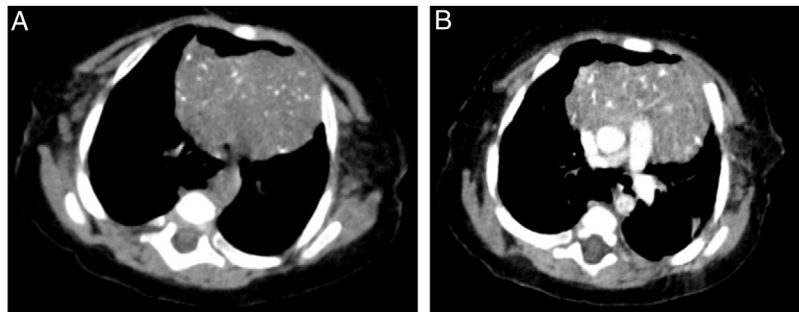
Axial computed tomography scan of the chest without contrast (A) and with contrast (B) evincing thymus hypertrophy. There were multiple punctate calcifications in the thymus, characteristic of Langerhans cell histiocytosis in this organ.
